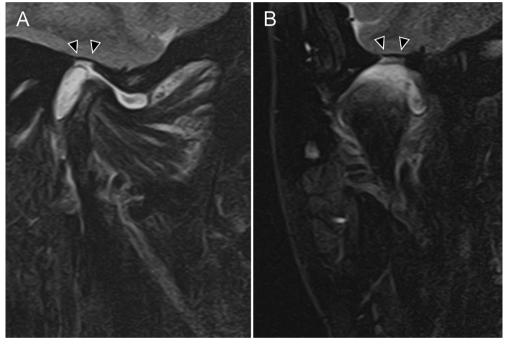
T2-weighted MRI of the right TMJ at the first visit: (A) sagittal view, (B) coronal view.
